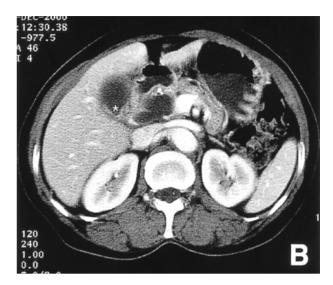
Computed tomographic scan of the abdomen demonstrates multiple thickenings of the gallbladder wall with intramural hypoattenuated nodules (arrows), which were subsequently demonstrated to be the result of a xanthogranulomatous inflammation (A). At the neck of the gallbladder, a focal irregular thickening of the wall is also noted (asterisk). This proved to be a carcinoma (B).
